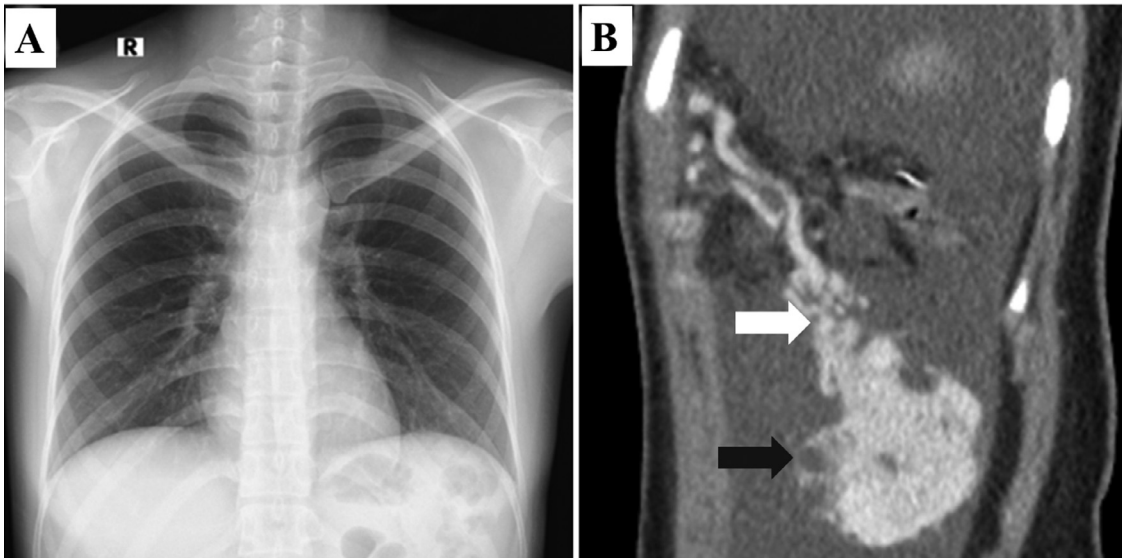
Chest X-ray and detection of a retroperitoneal solitary fibrous tumor via CT. (A) Anteroposterior chest X-ray showing no abnormal findings. (B) Sagittal contrast-enhanced computed tomography showing a serpiginous dilation of the right gastro-omental artery, which is the feeding artery (white arrow). Intratumoral cystic components are also present (black arrow).
